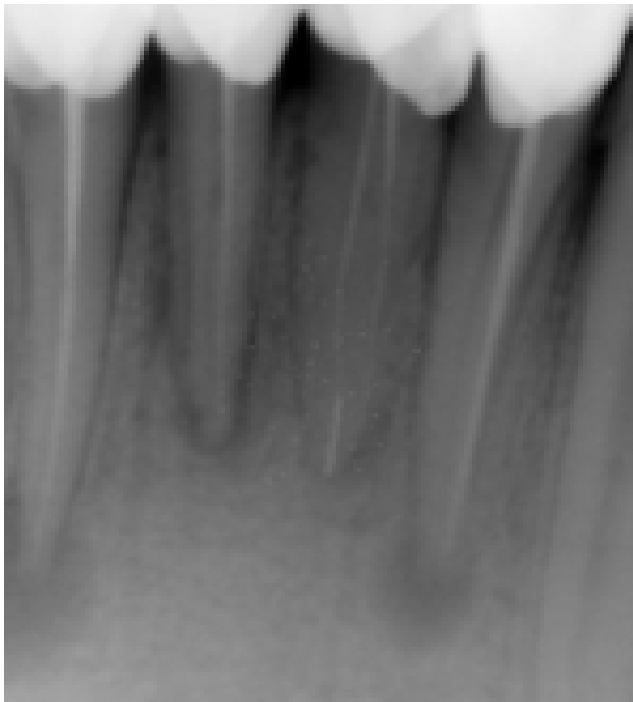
Preoperative radiograph of teeth (#32,31,41,42) with inadequate root canal treatment, periapical radiolucency, and instrument separation seen #31
